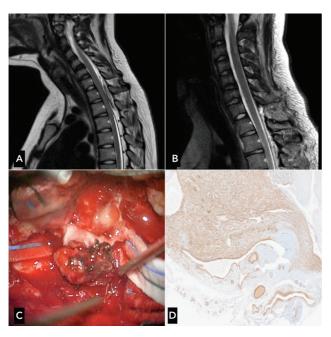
(A) Preoperative magnetic resonance (MR) of the cervical spine, T2-weighted sequence, sagittal plane showing posterior epidural collection of blood at the C7–T2 level with cord compression. (B) Postoperative MR of the cervical spine, T2-weighted sequence, sagittal plane, showing full expansion of the dural sac after complete removal of the cervical epidural hematoma without cord abnormalities. (C) Intraoperative image of abnormal compressive and bleeding nidus tissue found after laminotomy and decompression at C7 and T2. (D) Scanning magnification shows irregularly dilated and proliferated vessels; the cells of the vessel wall were positive for smooth muscle actin (SMA; $4 \times$).
